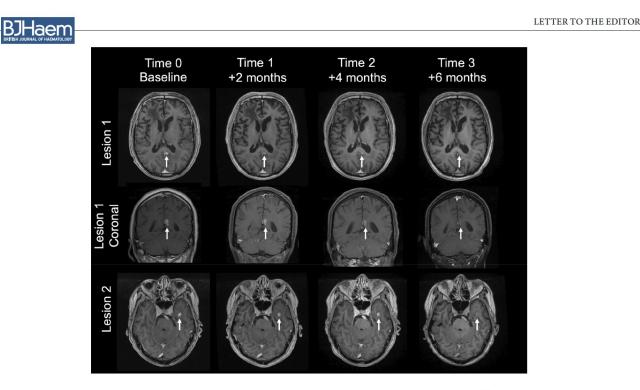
Regression of two lesions of highly refractory secondary central nervous system (CNS) lymphoma with tafasitamab plus lenalidomide. Axial spoiled gradient recalled echo (SPGR) and coronal spin-echo T1 post-contrast sequences are shown for Lesion 1 at the margin of the splenium of the corpus callosum with the left posterior cingulate cortex. Lesion 2 in the left anterior temporal lobe, shown on axial SPGR T1 post-contrast sequence, demonstrates similar time-dependent response to treatment. No perfusion imaging was obtained in this patient. A complete radiographic response on magnetic resonance imaging persists at 22 months since initial treatment with tafasitamab plus lenalidomide, markedly exceeding prior response durations with autologous stem cell transplant and lenalidomide maintenance, ibrutinib and combination ibrutinib plus lenalidomide.
